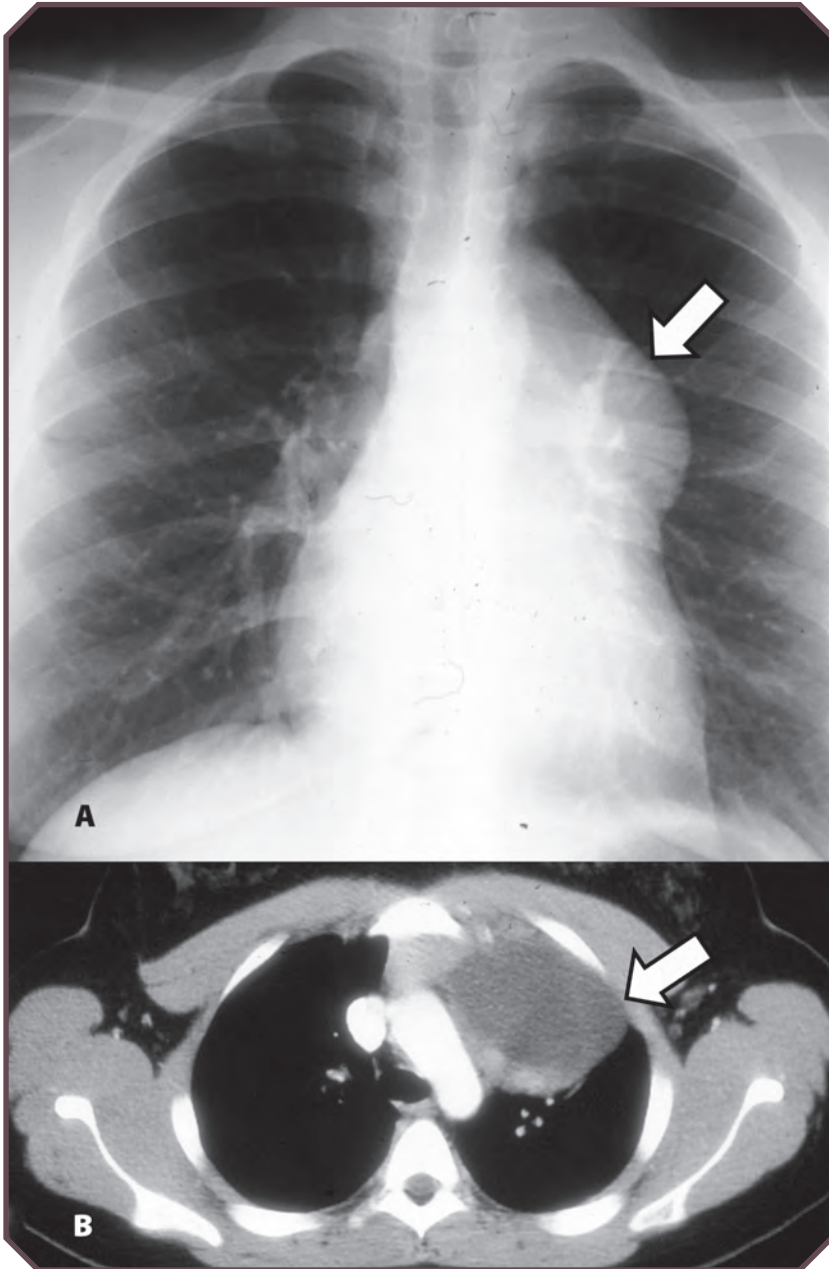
Bronchogenic cyst in a 12-year-old boy discovered incidentally. A. Frontal chest radiograph demonstrates a mass (arrow) overlying the left hilum, which is known as the “hilum overlay sign.” B. Axial contrast-enhanced chest computed tomographic image shows a unilocular, fluid-attenuated, anterior mediastinal mass (arrow) at the level of the aortic arch, adjacent to the thymus.
